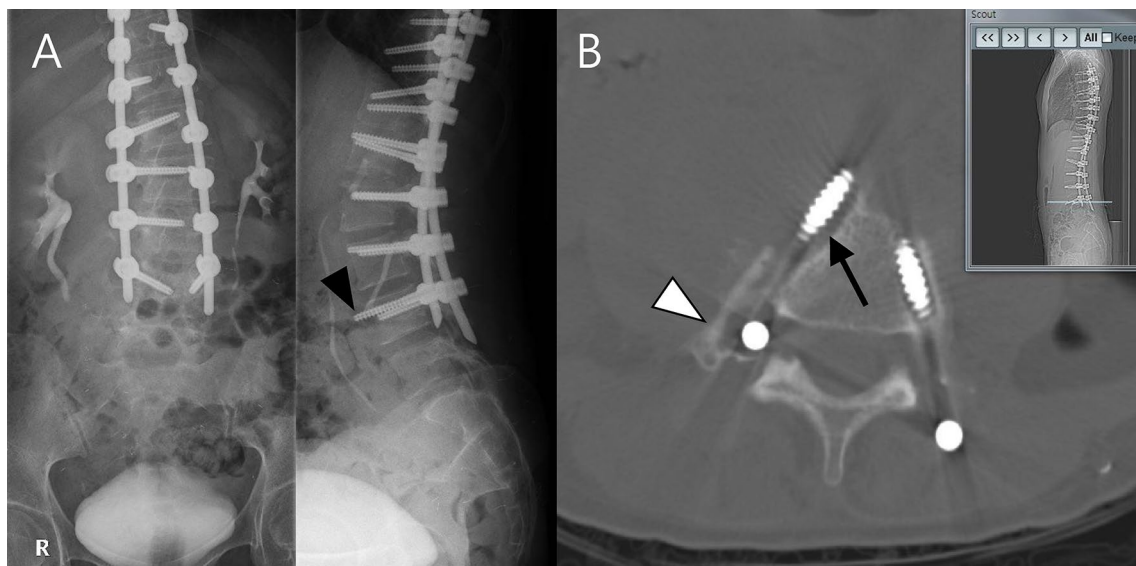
Lumbar spine X-ray and CT revealed that the right L4 pedicle screw (black arrowhead) was positioned too far anteriorly, with periscrew halo formation (black arrow), adjacent vertebral body erosion, and detachment of the transverse process (white arrowhead)
